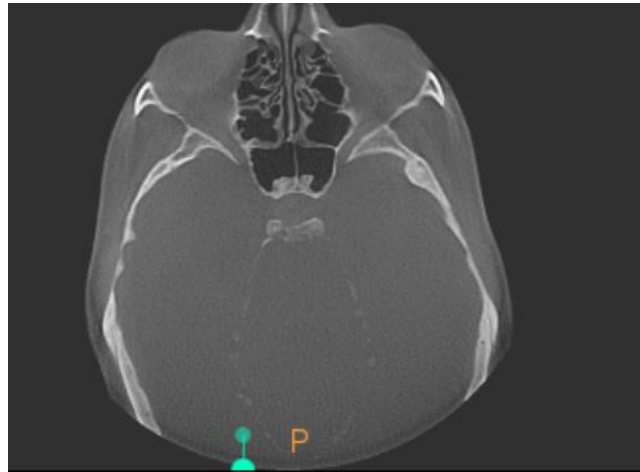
Axial CBCT section of the skull identifying a linear, crescent-shaped intracranial calcification of the falx cerebri.
